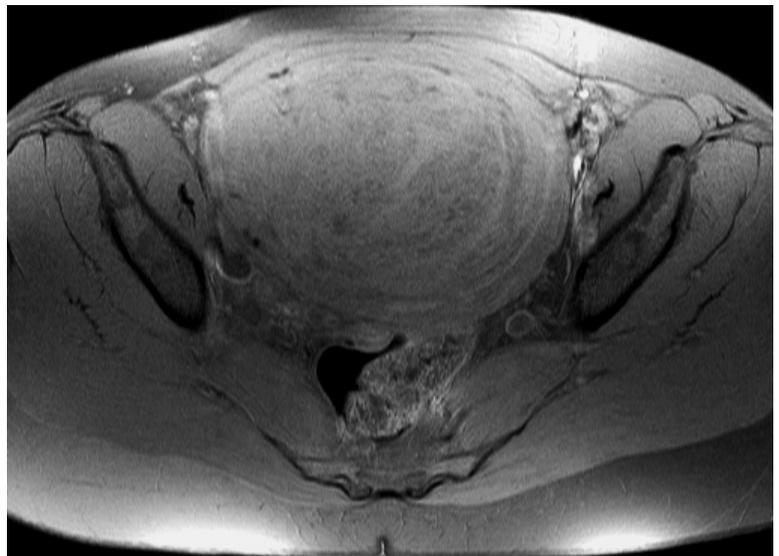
Signal intensity characteristics of leiomyoma. a T2-weighted transaxial image of the uterus (secretory phase of menstrual cycle) showing a subserosal leiomyoma with typical low signal intensity compared to adjacent myometrium. Note the bright signal of the endometrium and intermediate signal intensity of the junctional zone. b Corresponding T1-weighted transaxial image of the uterus showing intermediate signal intensity of the leiomyoma which can hardly be differentiated from the adjacent myometrium
